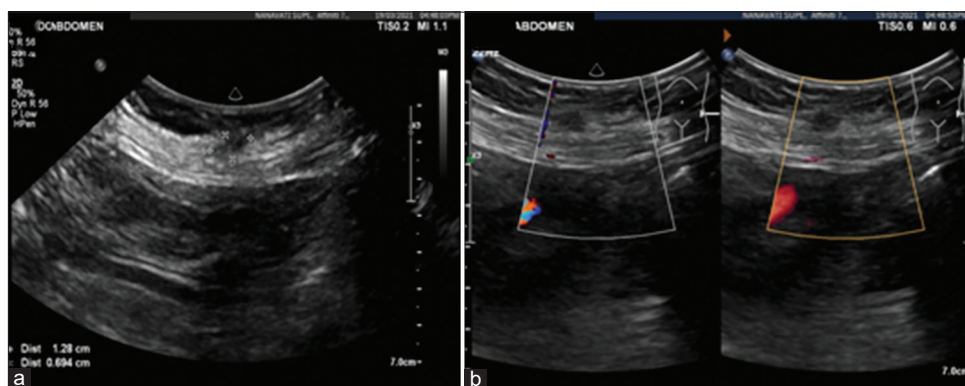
(a) USG showing focal lesion in the left iliac fossa at the level of deeper incision. (b) MRI imaging showing small nodular mass in subcutaneous plane in the left rectus abdominus muscle (case 2)
